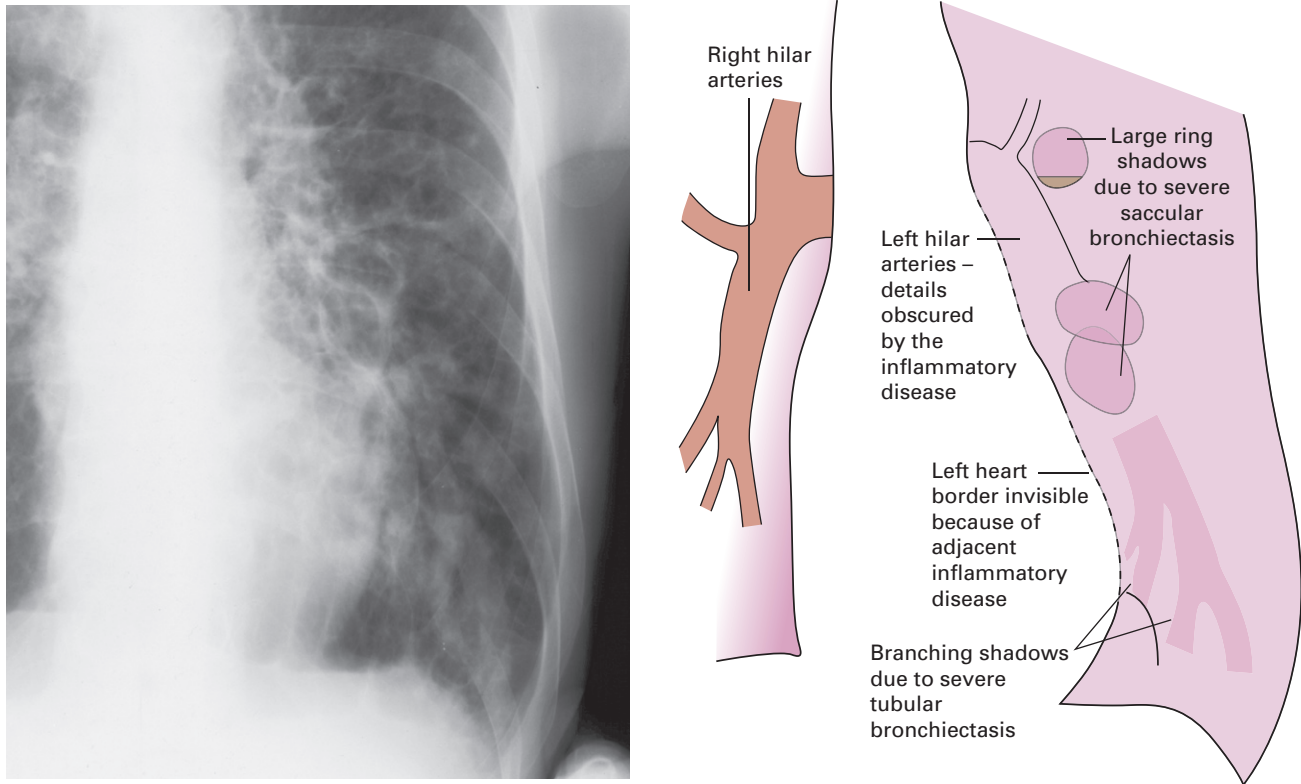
Bronchiectasis. Plain film showing a mixture of saccular and tubular bronchiectasis. The branching ectatic bronchi resemble large blood vessels but should not be confused with them.
